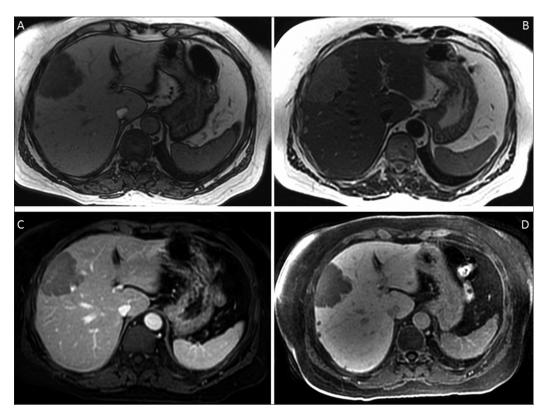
Hepatic adenoma. A, Axial T1-weighted-out of phase image shows in the right liver lobe a hypointense, fat containing lesion. B, Axial T2-weighted image shows slightly hyperintensity of the lesion. C, In the portal phase, after contrast media injection, the lesion appears hypointense. D, In the hepatobiliary phase, the lesion is definitely hypointense.
